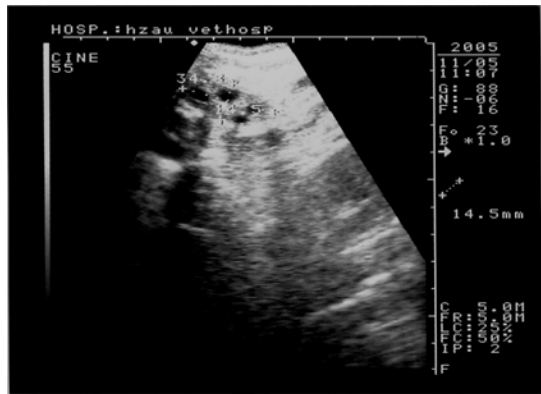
Ultrasonography of inactive ovary. Right ovarian ultrasonography obtained with 5.0 MHz intrarectal transducer. Ovarian size was 14.5×34.3 mm. Some small follicles distributed but no one developed
